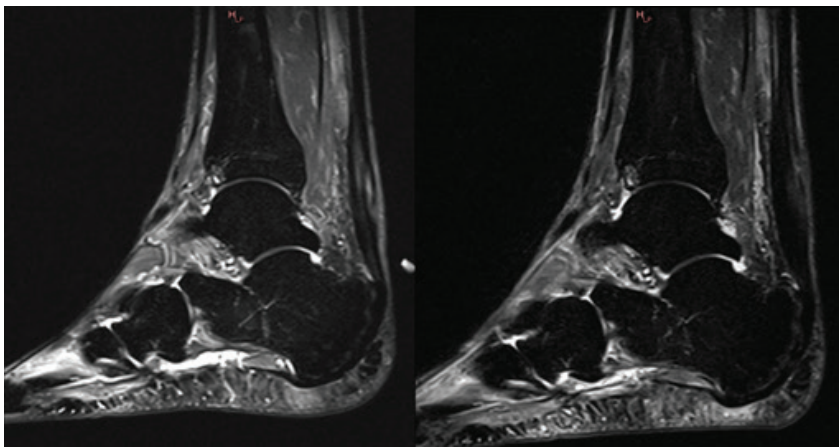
Sagittal STIR MRI showing Achilles tendinopathy and medial aspect tear 4.2cm above the insertion. Two months later, the Achilles showed dramatic healing with decrease in size of tear.
